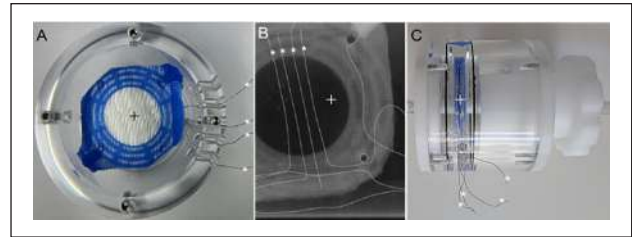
View of modified RatOx. A: Top view. B: Axial CT-scan. C: Lateral view. Hollow fiber mat bundle (+) with integrated sensor fibers.
